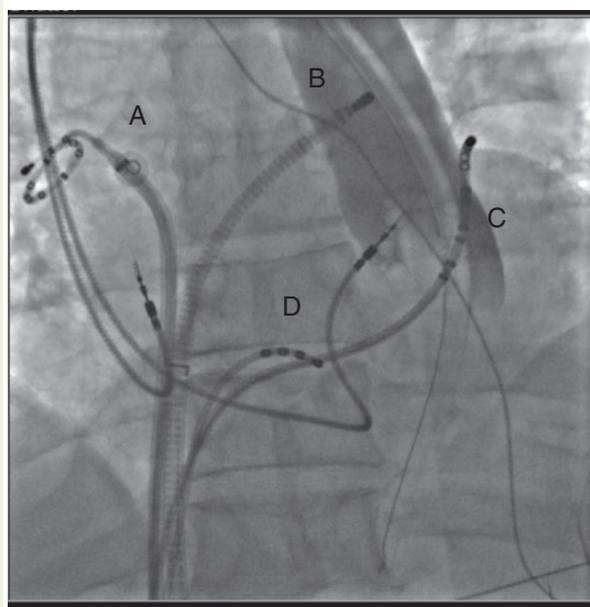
Direct visualization (postero-anterior view) of the same patient as Figure 1 at the time of ablation. The ring catheter (A) is positioned at the os of the right PV and the ablation catheter (B) at the left PV os. The coronary sinus catheter (C) and His catheter (D) are also visualized and dual-chamber pacemaker leads are also seen. Contrast has been given to delineate the position of the oesophagus. In real time the left upper PV is seen lying directly over the oesophagus compared with the midline position in the pre-acquired CT (Figure 1). This was one of the more extreme cases of oesophageal mobility between the two imaging modalities we encountered. Dual-chamber pacemaker leads are also seen *in situ*.
